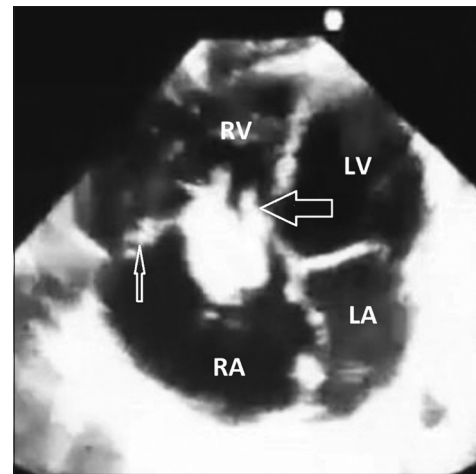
Vegetation (thick arrow) on tricuspid valve (thin arrow) in two-dimensional echocardiography. LA: Left atrium, LV: Left ventricle, RA: Right atrium, RV: Right ventricle
